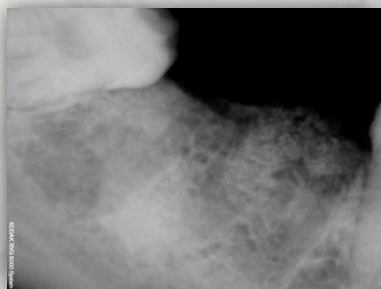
Two month post-operative radiograph
